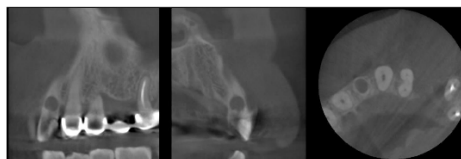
CBCT images of the tooth before treatment
